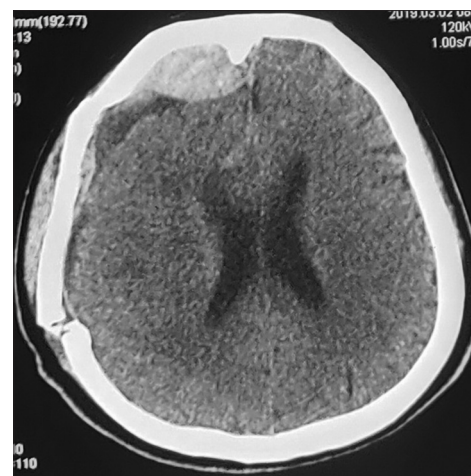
Postoperative computed tomography scan showing good evacuation of epidural hemorrhage, small new postoperative epidural hemorrhage with hyperdensity (HU 78) indicating the correction of hypofibrinogenemia in postoperative period
